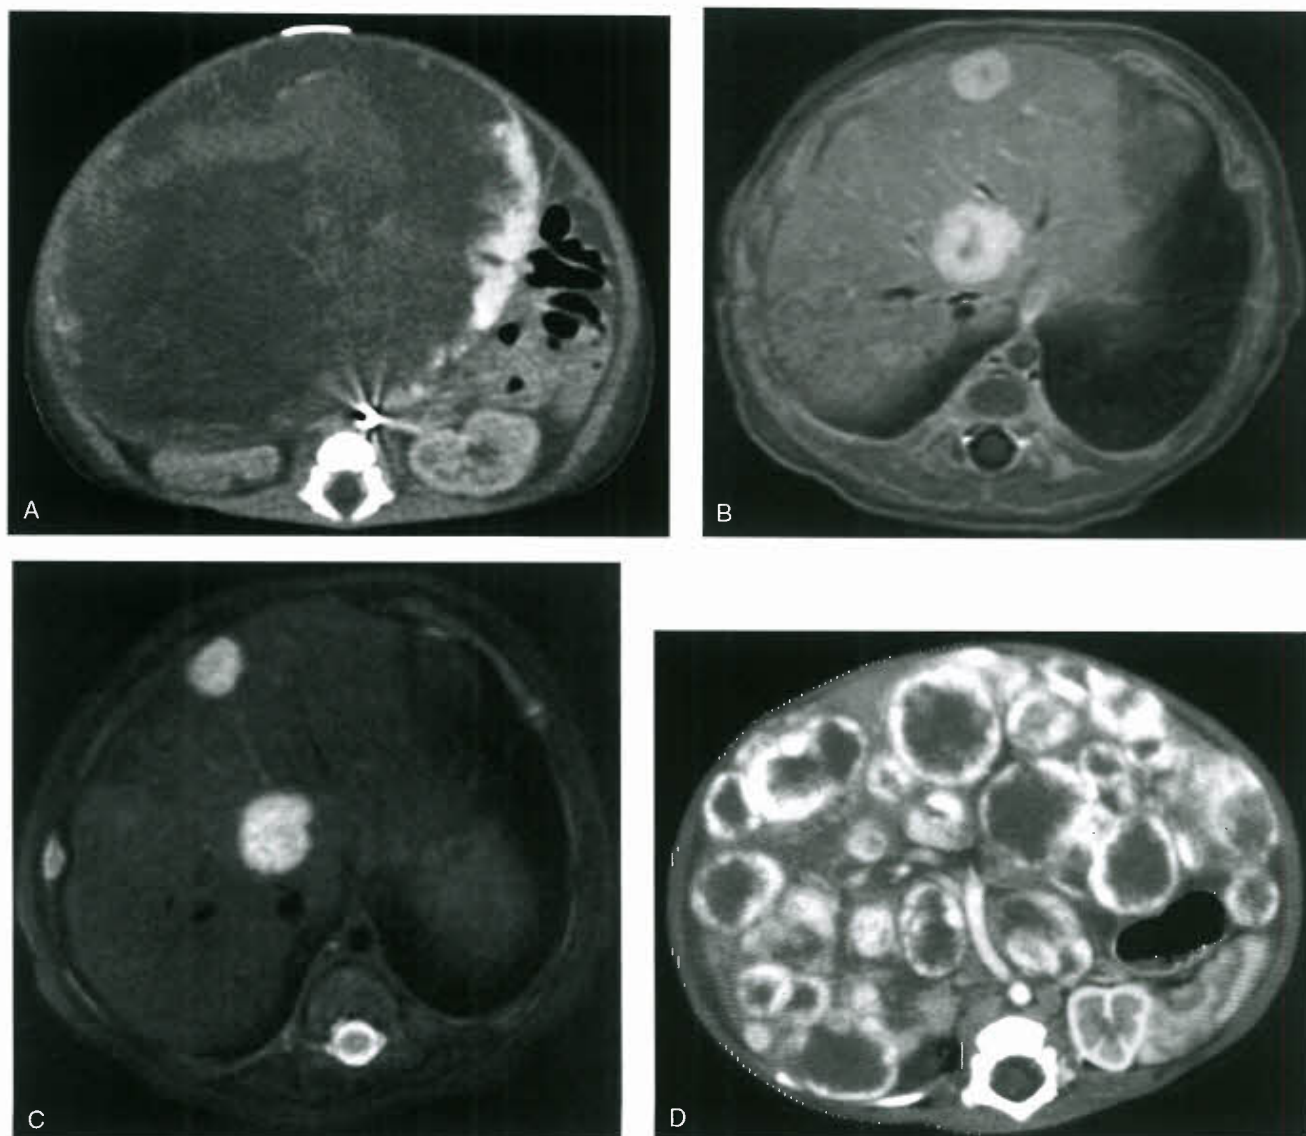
Liver hemangiomas. A: Hepatic RICH. Enhanced CT scan shows huge hypodense mass in the right lobe of the liver. Note peripheral enhancement and subcapsular locations. B,C: Multifocal hepatic infantile hemangioma. T2 and postcontrast T1 sequences demonstrate two focal, well-defined T2 hyperintense lesions that enhance following contrast administration. D: Diffuse hepatic infantile hemangioma. Enhanced CT scan reveals numerous, hypodense masses with peripheral enhancement almost completely replacing the liver parenchyma.
